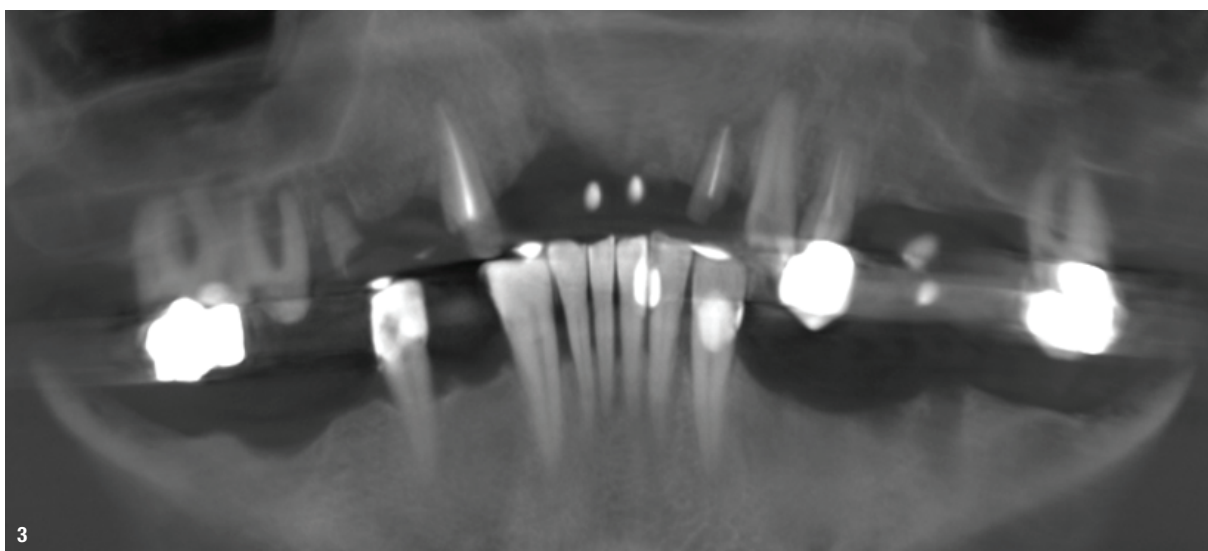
Initial radiographic view.
